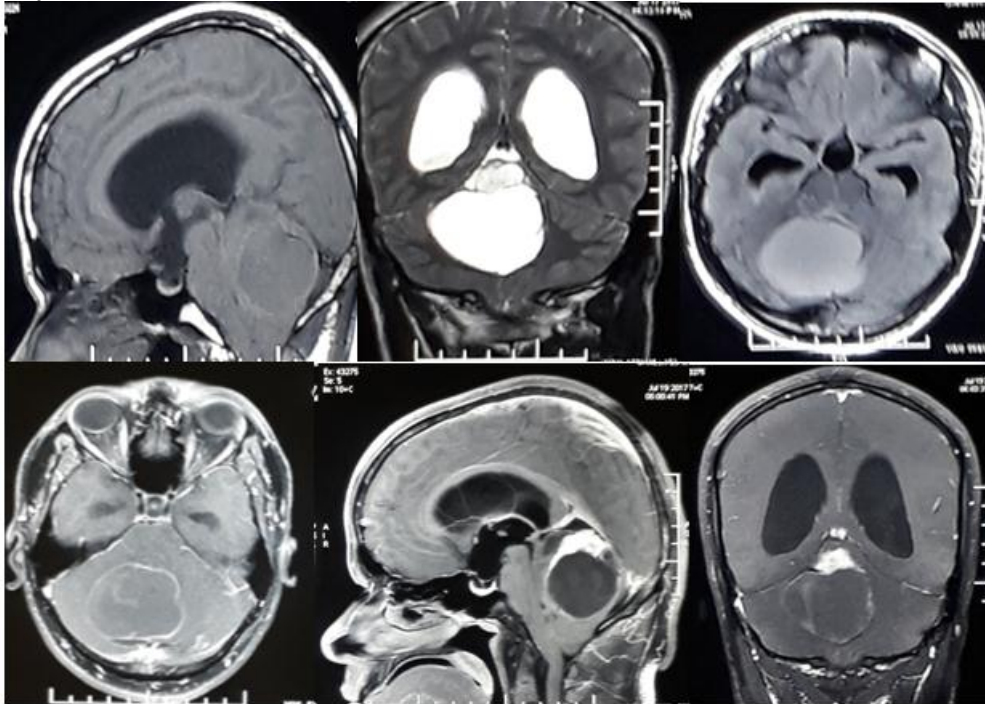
a) Plain and Contrast MRI Brain showing Posterior fossa, right medio-cerebello-vermian region intra-axial, predominantly cystic lesion.
